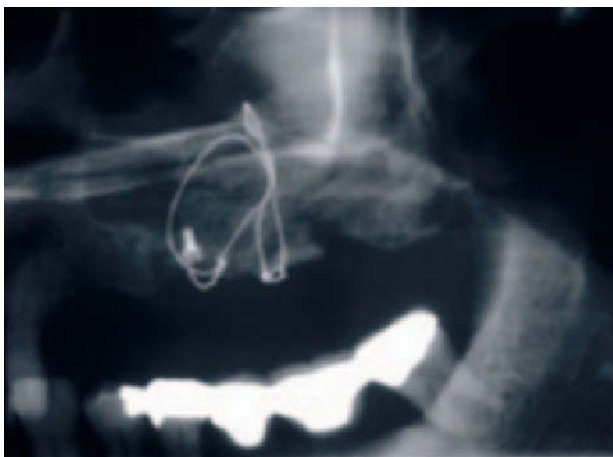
Radiograph showing the bone graft in position.
